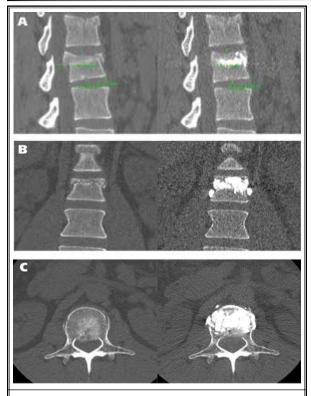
Preoperative and postoperative lateral computed tomography (CT) scan (5A), preoperative and postoperative anteroposterior CT scan (5B), operative CT scan (5C).
